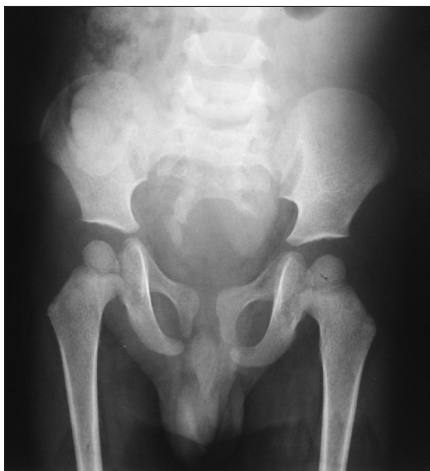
Plain pelvic X-ray (anterior - posterior view) showing a hemisacral defect and an intact first and second sacral bones
